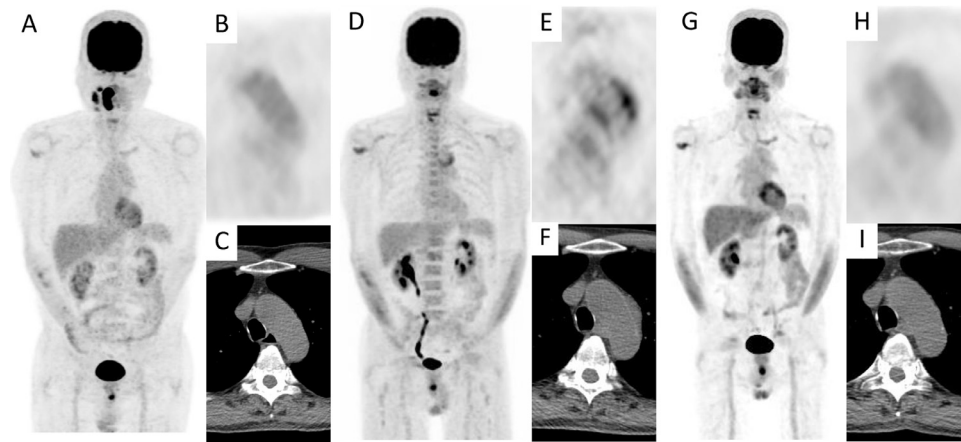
Figure – (A-C) Results from the first round of ^{18}F -FDG PET/CT. The lymphoma lesions (right tonsil and enlarged right cervical lymph node) showed FDG accumulation, and there were no signs of aortitis. (D-F) Results from the second round of ^{18}F -FDG PET/CT, performed after chemotherapy. Fourteen days after the last administration of G-CSF (pegfilgrastim), wall thickening of the aortic arch and FDG accumulation were observed, as well as physiological diffuse FDG accumulation in the bone marrow. (G-I) Results from the third round of ^{18}F -FDG PET/CT, performed after chemotherapy. The wall thickening improved and FDG accumulation decreased.
